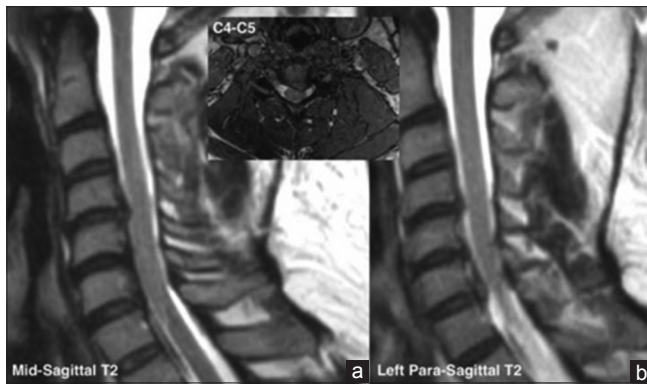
Midsagittal magnetic resonance imaging (a) demonstrating left C4–C5 paracentral disc herniation with spinal cord compression (inset). Parasagittal magnetic resonance imaging (b) demonstrating left C5–C7 foraminal stenosis and lateral recess stenosis dorsal to the vertebral body of C5 and C6
